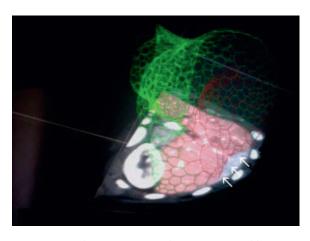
Working view at 3D editing. Segmented liver surface is represented by a mesh graft; additionally, the spiral CT source data, as well as the liver contour on the spiral CT data, can be seen. White arrows mark the area where the automated segmentation process failed to detect the liver contour
